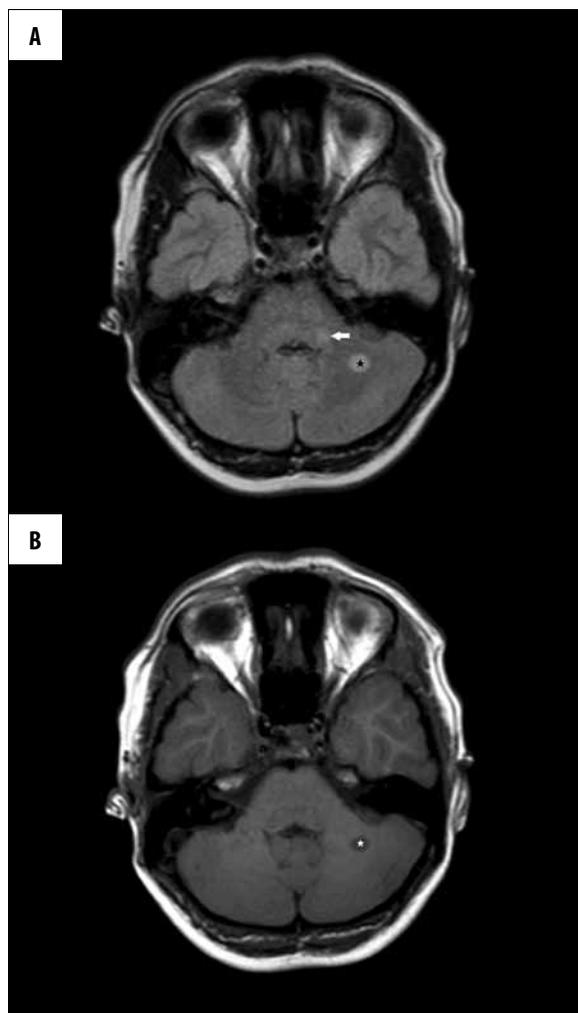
14-year-old girl, MRI brain scan: (A) FLAIR FSE sequence image, transverse plane, (B) T1-weighted SE image, transverse plane. Demyelinating foci in the cerebellum left hemisphere (star) and in the left cerebellar peduncle (arrow).
